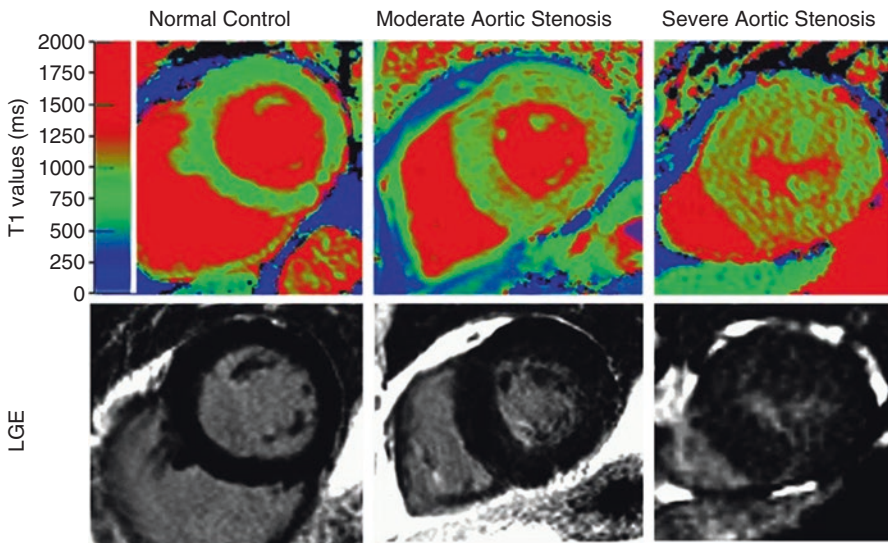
T1 mapping and late gadolinium enhancement MRI depict regions of high collagen content and fibrosis. This can be seen in aortic valve images from patients. This figure shows three cases in order of increasing fibrosis: a normal control, moderate aortic stenosis, and severe aortic stenosis. (This work is attributed to Bull et al. and used under a Creative Commons Attribution-NonCommercial 3.0 Unported license [7])
